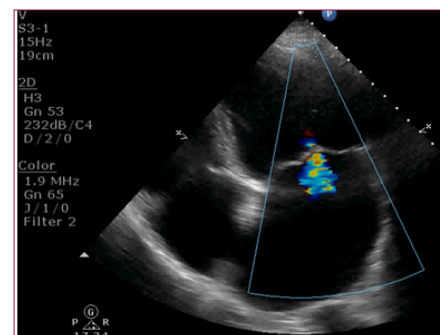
Echocardiogram, left atrial enlargement and mitral insufficiency.
